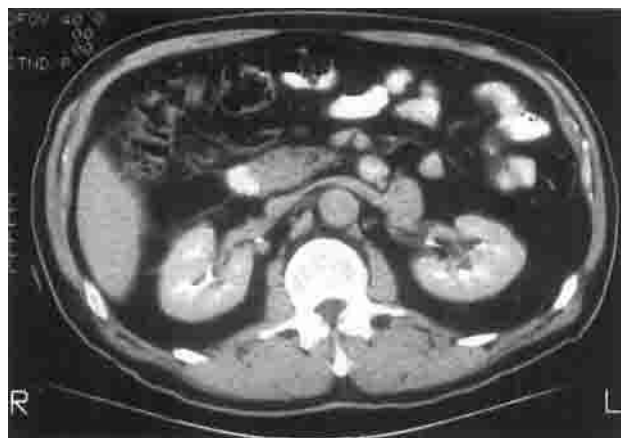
Case 2: On initial presentation, computed tomography of the abdomen showing a 2 cm mass contiguous with the left renal vein.
